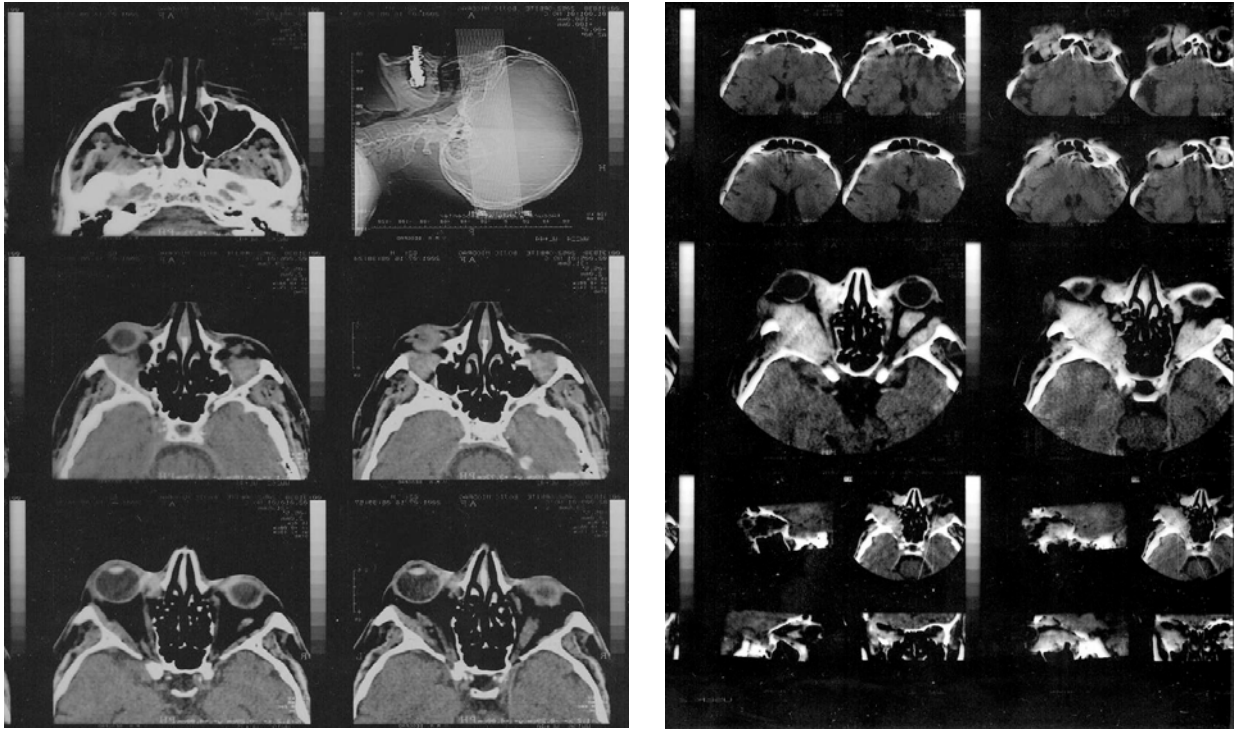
Computed tomography depicting protrusion of the left bulb with tumor mass lesion diameter 3.8 × 1.6 cm of the lateral wall of the left orbit. The lesion is strongly enhanced after contrast injection.
